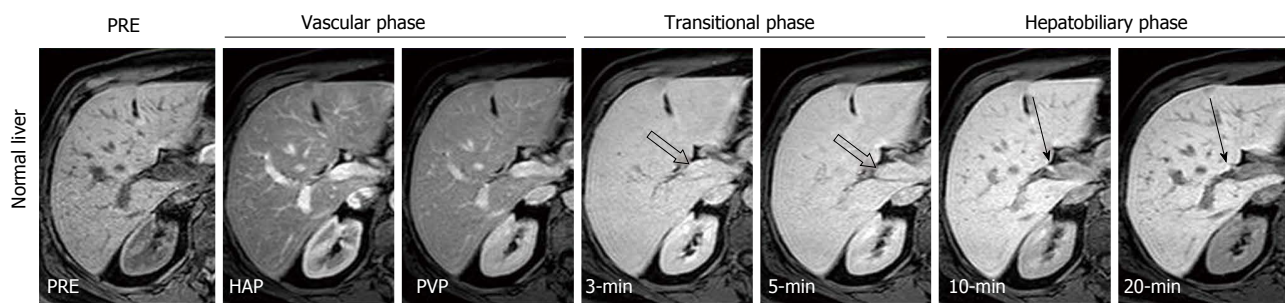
Gadoxetic acid contrast-enhanced magnetic resonance images obtained in a 46-year-old woman with normal liver. Contrast-enhanced magnetic resonance images show a stepwise intensity increase of the liver parenchyma from the hepatic arterial phase to hepatobiliary phase. On hepatic arterial and portal venous phases (vascular phase), the intrahepatic vessels show intense and homogeneous enhancement. On 3 min late and 5 min late phases (transitional phase), the intrahepatic vessels (open arrows) show isointensity to the liver, indicating the transition of gadoxetic acid from the extra-cellular spaces to the hepatocellular-spaces. On 10 min and 20 min phase (hepatobiliary phase), the intrahepatic vessels show hypointensity to the liver, while the bile ducts (arrows) show hyperintensity; these findings indicate an adequate hepatobiliary phase. Also note kidney hypointensity to the liver, which indicates normal hepatobiliary elimination of gadoxetic acid and adequate hepatobiliary phase. PRE: Precontrast; HAP: Late hepatic arterial phase; PVP: Portal venous phase.
